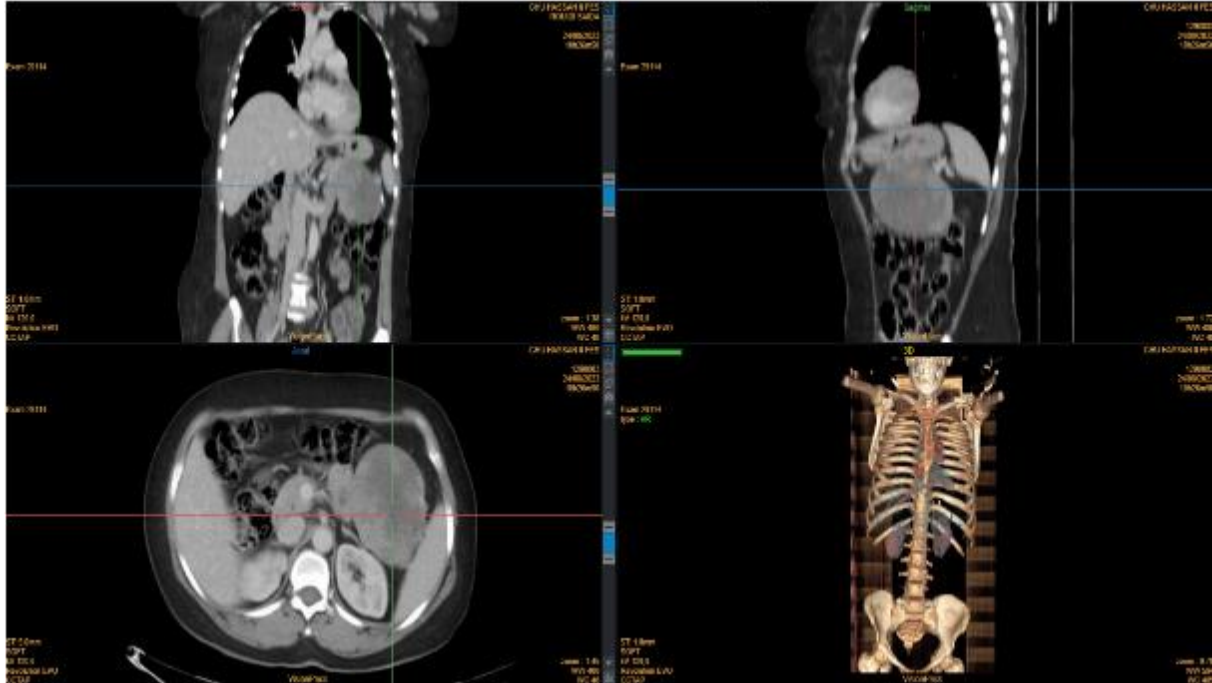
CT scan: Axial, coronal and sagittal views with 3d reconstruction
